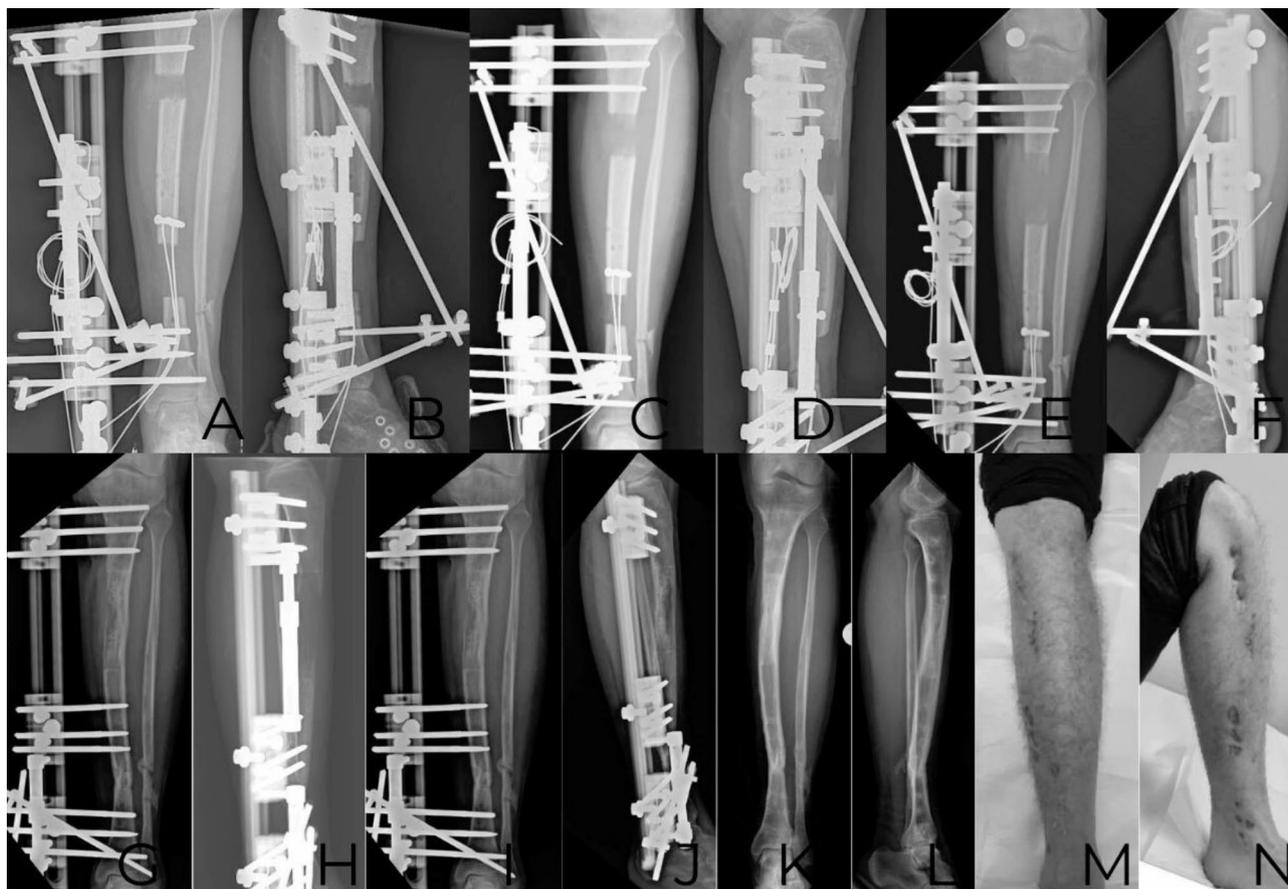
(A-N) A 25-year-old male patient with a 7 cm defect in the tibia after a Type 3 A open fracture of the left tibia caused by a motor vehicle accident. Bone transport with cable-assisted bone transport; (A-F) Segment transport with cable-assisted technique, (G-J) Regeneration and union at the docking site, (K-N) final follow-up radiograph and functional status
